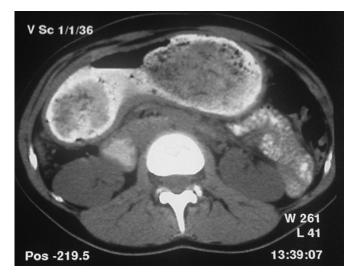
Preoperative CT scan image, transversal aspect
